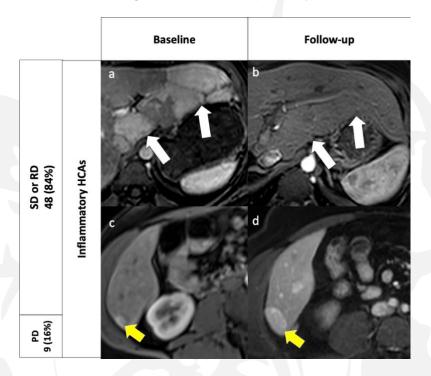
Representative images of size changes of inflammatory hepatocellular adenomas. Outcome of patients with only inflammatory hepatocellular adenomas in our study is also represented in number and percentages on the left. Top row: 30-year old woman with hepatocellular adenomas; axial contrast-enhanced MRI images at baseline (a) and at 4-year follow-up (b) demonstrate substantial regression of inflammatory hepatocellular adenomas (white arrows). Bottom row: 41-year old woman with hepatocellular adenomas; axial contrast-enhanced MRI images at baseline (c) and at 6-years follow-up (d) demonstrate a substantial progression of an inflammatory hepatocellular adenoma (yellow arrows).
